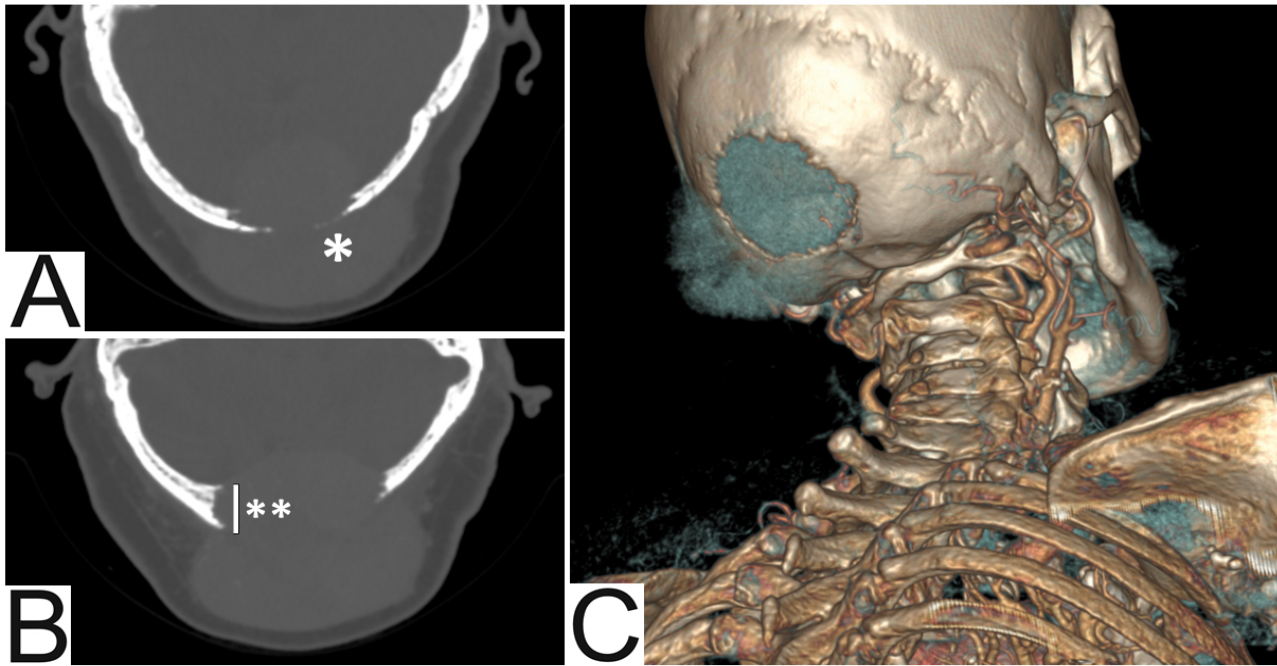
CT scan demonstrating trabecular and cortical osteolysis. A, B) Axial images from a non-contrast CT scan using bone algorithm. Destructive osteolysis with cortical breakthrough at the occipital squama. Axial computed tomography (CT) scan with bone window depicts inner and outer table scalloping, thinning and interruption (*). The “punched-out” lesion expands the intradiploic diameter at the bone margins (), suggesting intradiploic origin. C) CT MPR 3D reconstruction showing the defect in the occipital bone, located about three centimeters behind the foramen magnum. GE Revolution EVO 64 CT scanner.
